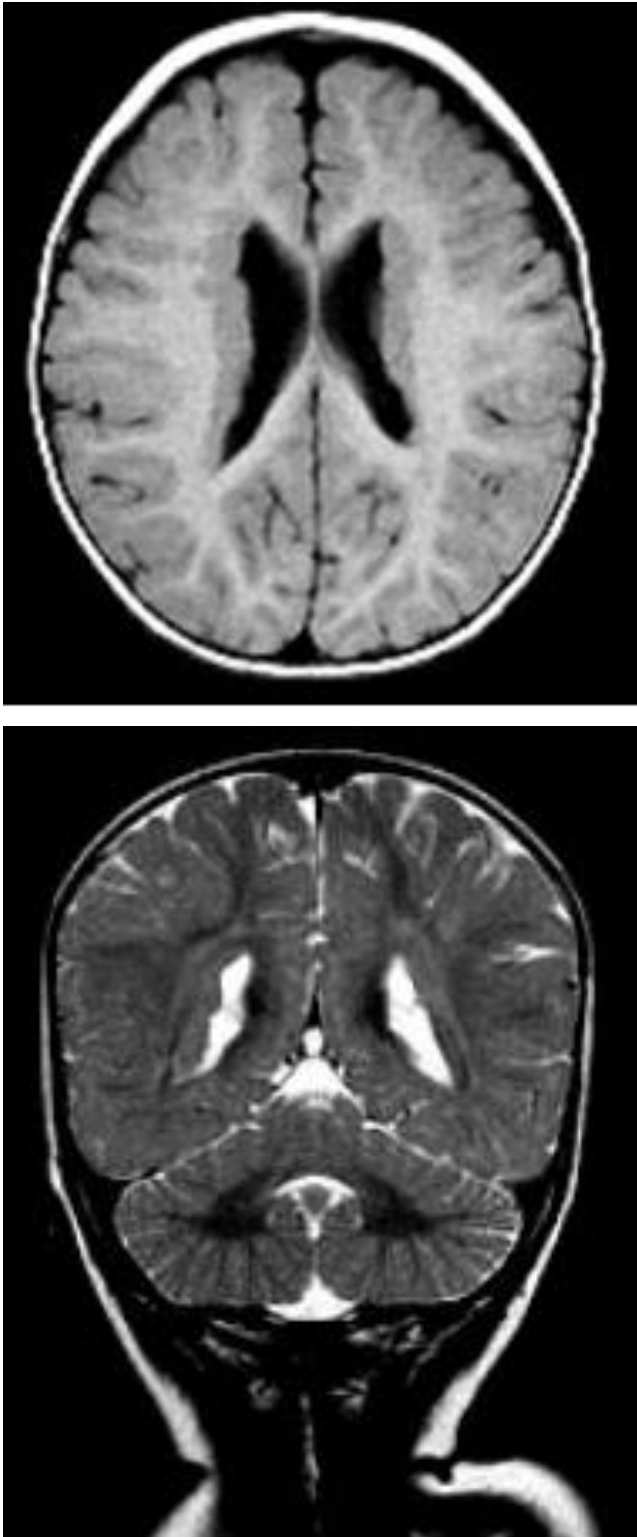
T1 and T2 MRI images of the 1 year old child demonstrating multiple uncalcified nodules on the lateral ventricular walls (the intensity of the nodules was the same as that of the cerebral gray matter).
